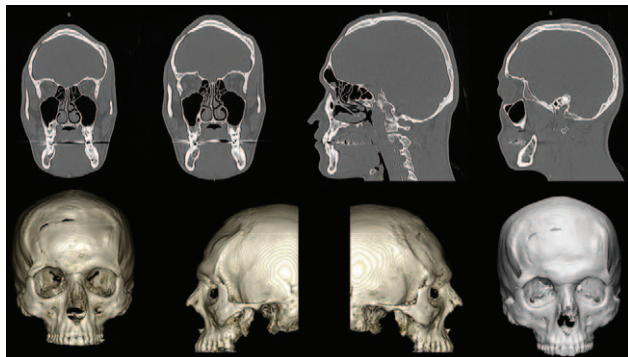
Computed tomography scans at diagnosis before reconstructive surgery.
